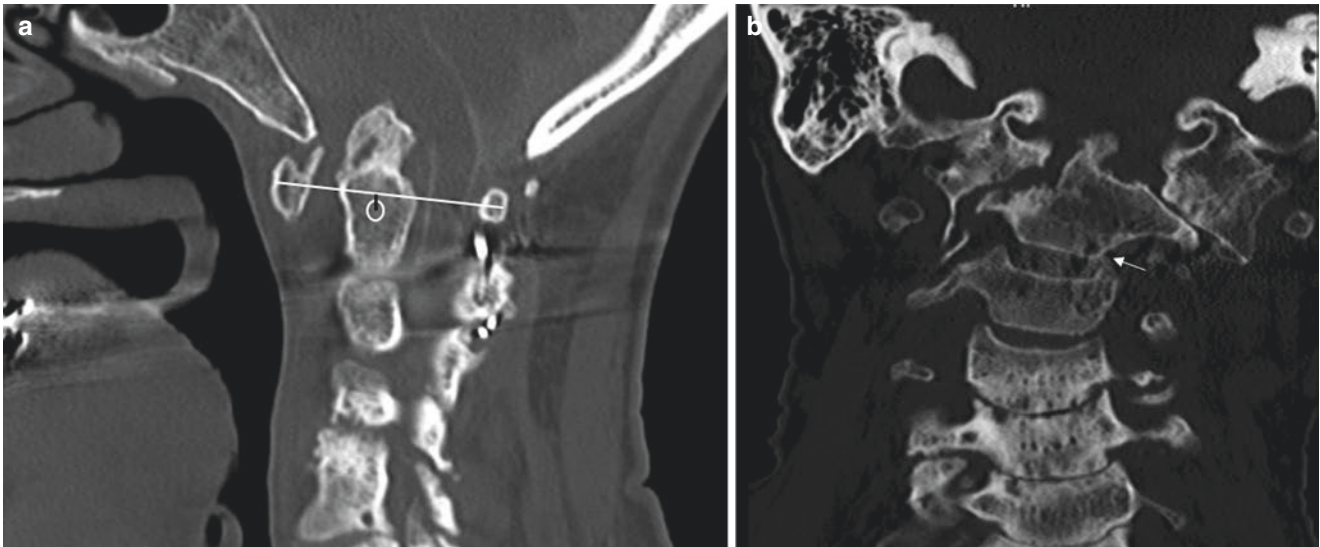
Computed tomography myelogram of cervical spine showing (a) vertical atlanto-axial subluxation (AAS) and (b) lateral AAS
